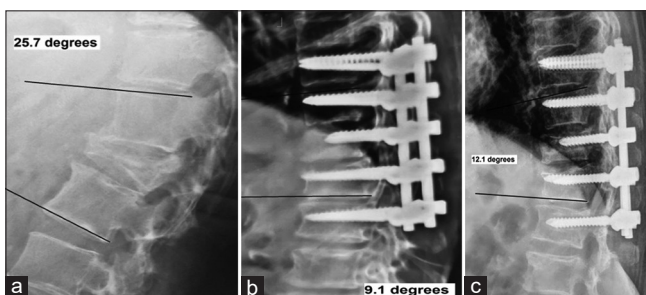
(a) A 75-year-old female presented with Frankel Grade C neurology. Preoperative radiograph depicted osteoporotic D12 fracture with local kyphosis of 25.7°; (b) 6 weeks postoperative radiograph with posterior fixation and instrumentation of fracture body with correction of local kyphosis to 9.1°; (c) two years follow-up lateral radiograph demonstrating healed fracture with slight loss of correction. Patient is ambulatory and able to perform activities of daily living
